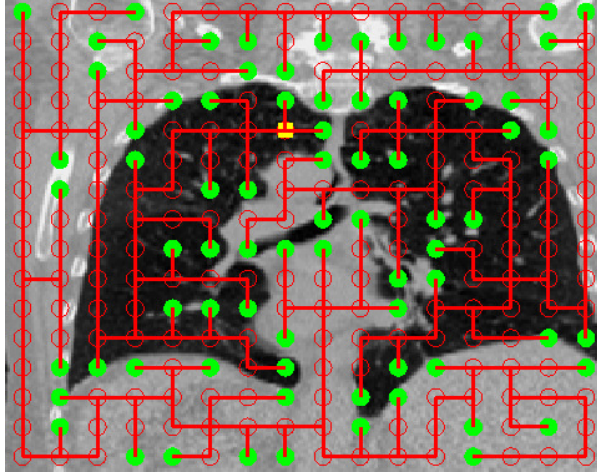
The MST corresponding to a 2D coronal slice from a Dynamic CT image of the lung. The leaf nodes are represented in green, and the root is represented in yellow.*
